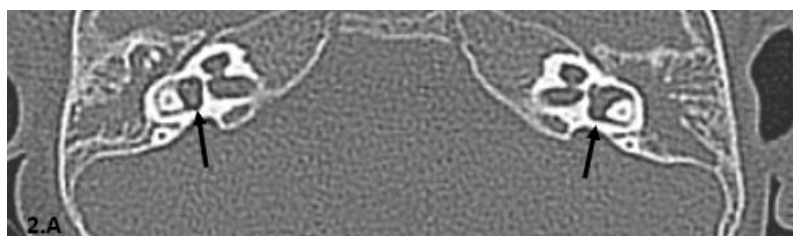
A: Axial CT, bone window view revealed bilateral normal vestibules (black arrows).
